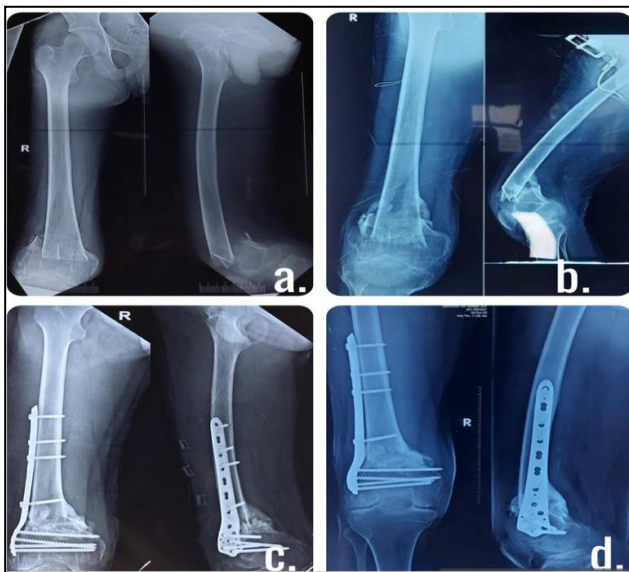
(A-D): X-ray right knee with thigh (AP and lateral view): On the day of trauma, malunion at fracture site, post operative day 1 and one year after surgery during follow-up.
